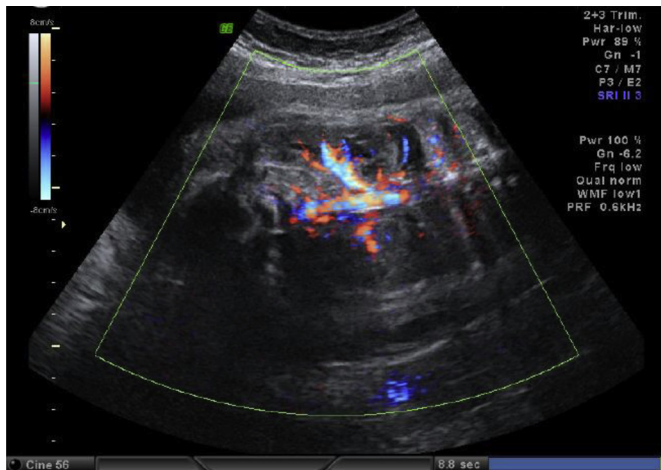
Fetal ultrasonography showed duplex kidney, left.
